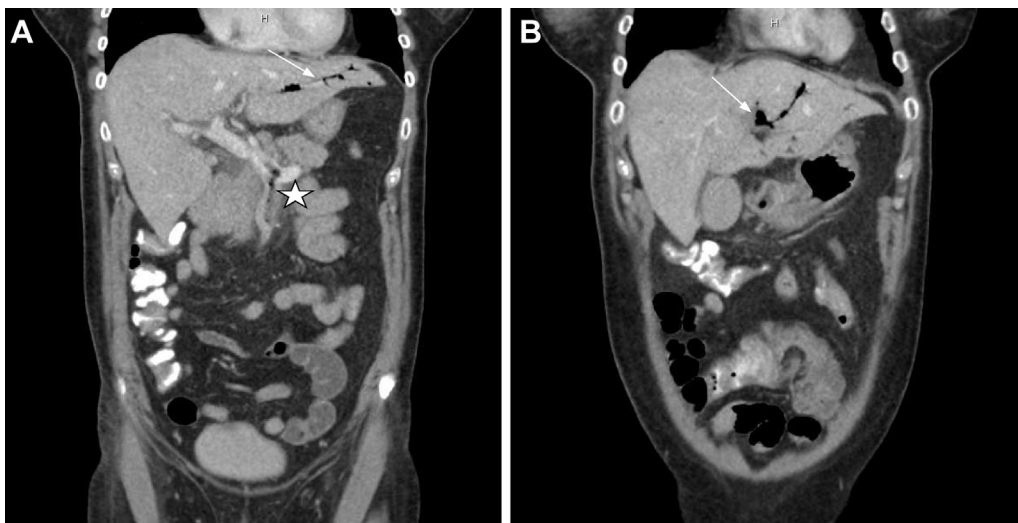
A, Third computed tomography (CT) scan. Contrast-enhanced coronal image shows extension of superior mesenteric vein (SMV) thrombus into portal system (*star*) and portal venous gas (*arrow*). B, Additional coronal slice from same scan with obstructed left portal vein and additional portal venous gas.
